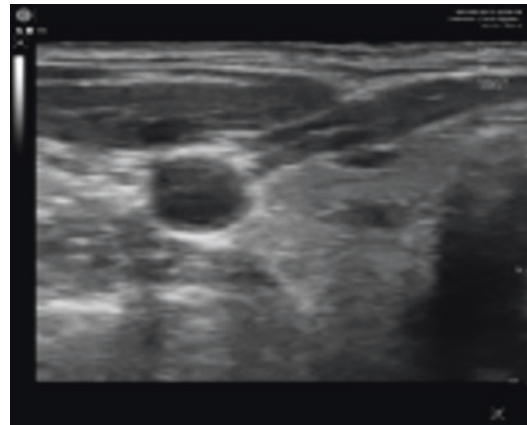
This is an ultrasound image of a thyroid nodule and a midgland lesion that does not have well-defined encapsulation (possible cancer) so follow-up is recommended
